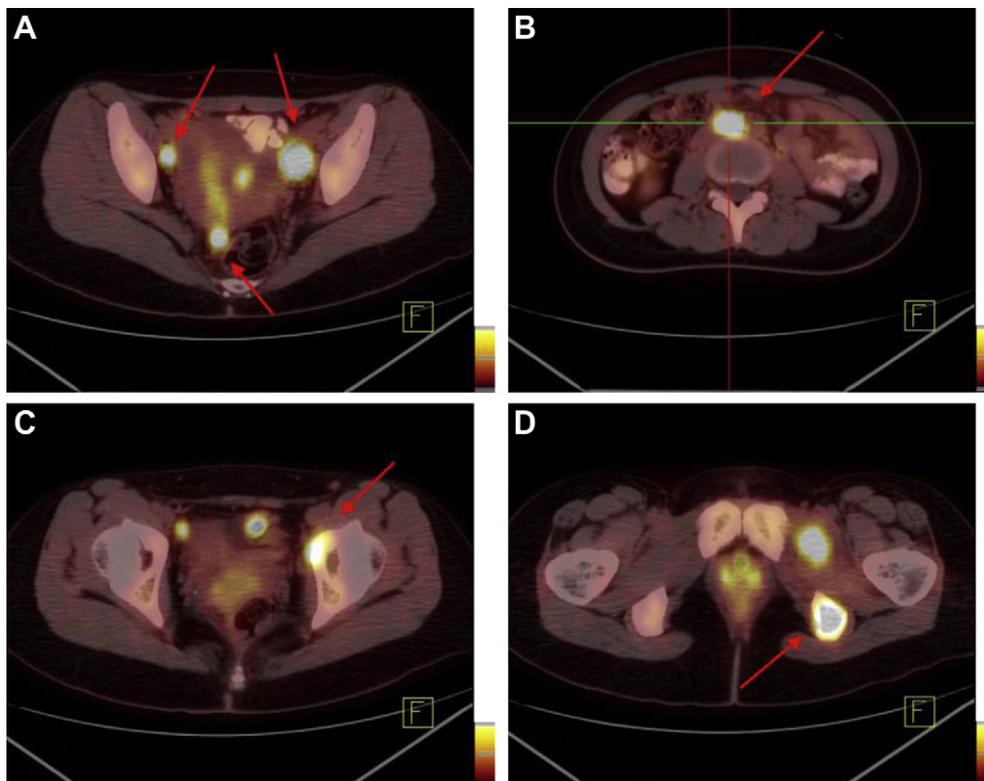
Positron emission tomography-computed tomography showed increased uptake at (A) the bilateral iliac lymph nodes and the left presacral soft tissue, (B) the para-aortic lymph nodes, (C) the left acetabulum, and (D) the left ischium. The red arrows reveal the lesion sites.
